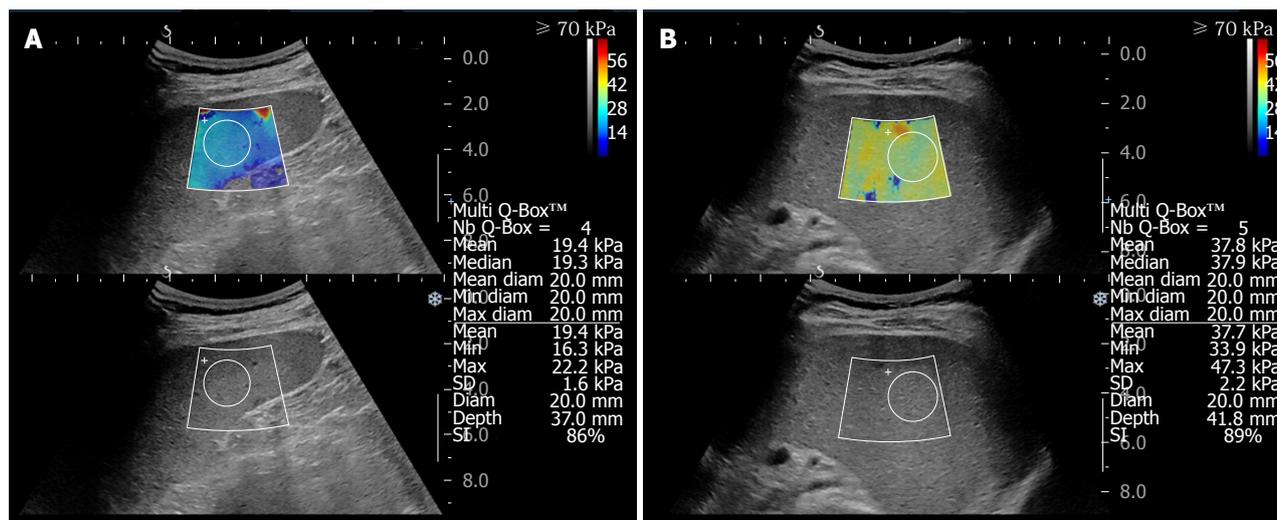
Spleen two-dimensional shear wave elastography images. Spleen 2D-SWE images of a 50-year-old male patient with normal SS (A) and 57-year-old female patient with liver cirrhosis who underwent endoscopic variceal ligation (B). A. The normal patient had a small size and measurable area of spleen. And the SS was measured to 19.4 kPa. B. Patient with liver cirrhosis had relatively large size and measurable area of spleen with good sonographic window. Increased spleen stiffness compared with that of normal patients was identified (37.7 kPa). 2D-SWE: Two-dimensional shear wave elastography; SS: Spleen stiffness.
